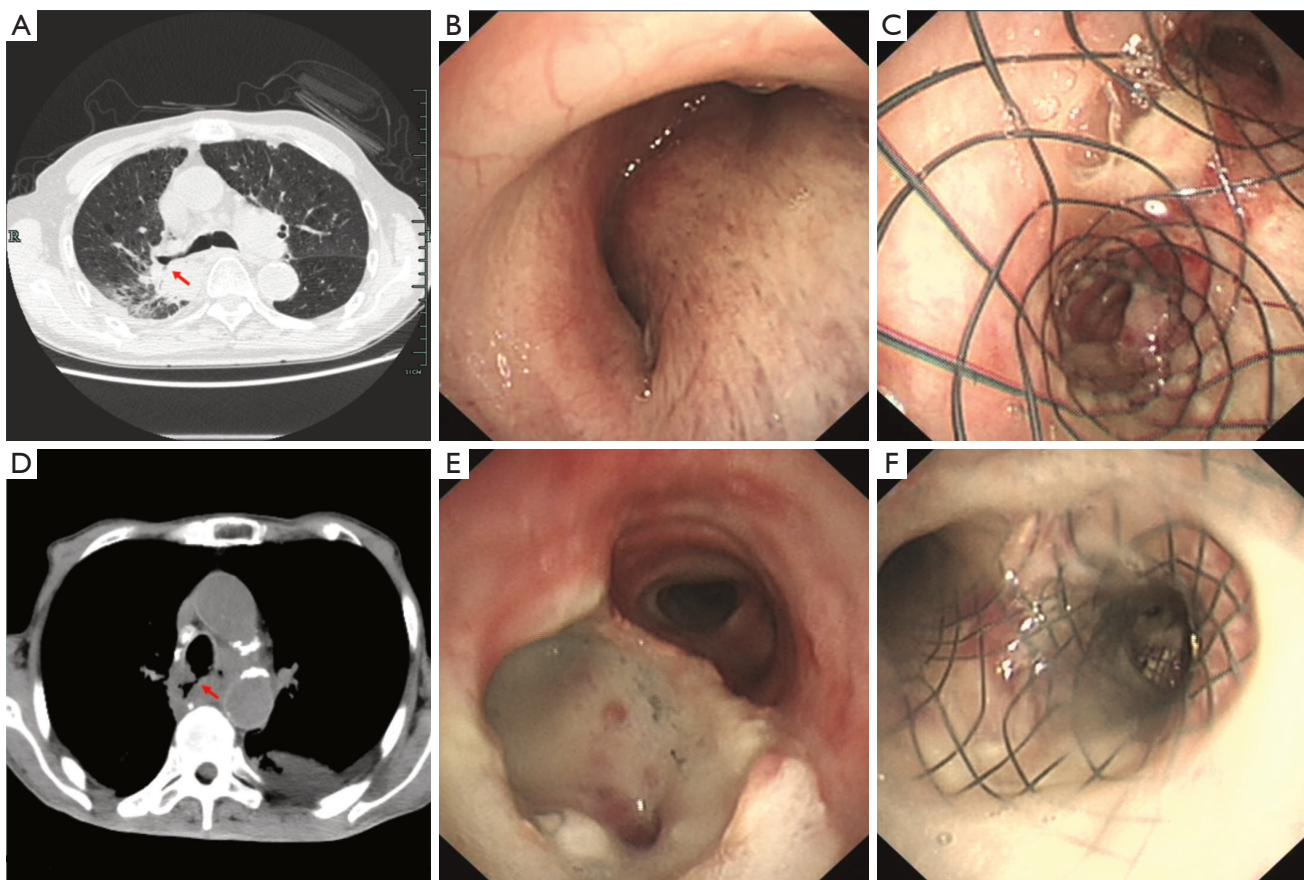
The treatment of extrinsic compression and thoracostomach-tracheal fistula. (A) Computed tomography (CT) scan showed the extrinsic compression of right lobar bronchi (arrow); (B) the bronchoscopy revealed the severe bronchial stenosis; (C) a Y-shaped stent was inserted at the lobar bronchi to maintain patency; (D) spiral CT reconstruction before intervention showed a thoracostomach-tracheal fistula at the carina (arrow); (E) the bronchoscopy revealed the secretion was flowing into the airway through the partial tracheal defect; (F) a covered Y-shaped stent was inserted at the carina.
